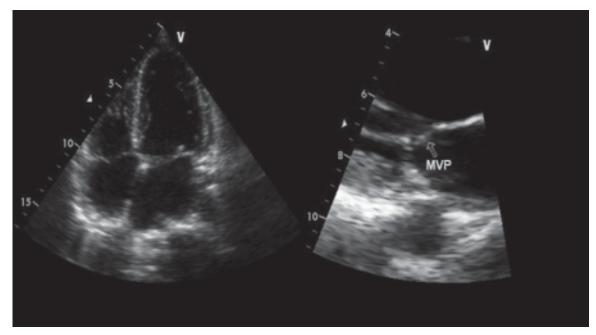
Transthoracic echocardiography revealed mitral valve prolapse. MVP, Mitral Valve Prolapse
